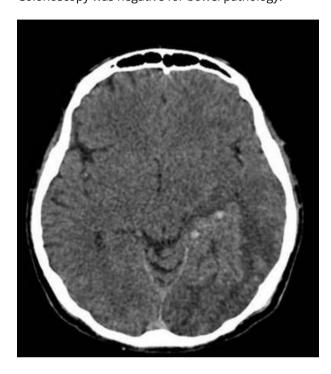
Plain CT scan of brain showing heterogeneously hypodense mass lesion in multiple vascular territories with multiple haemorrhagic foci
